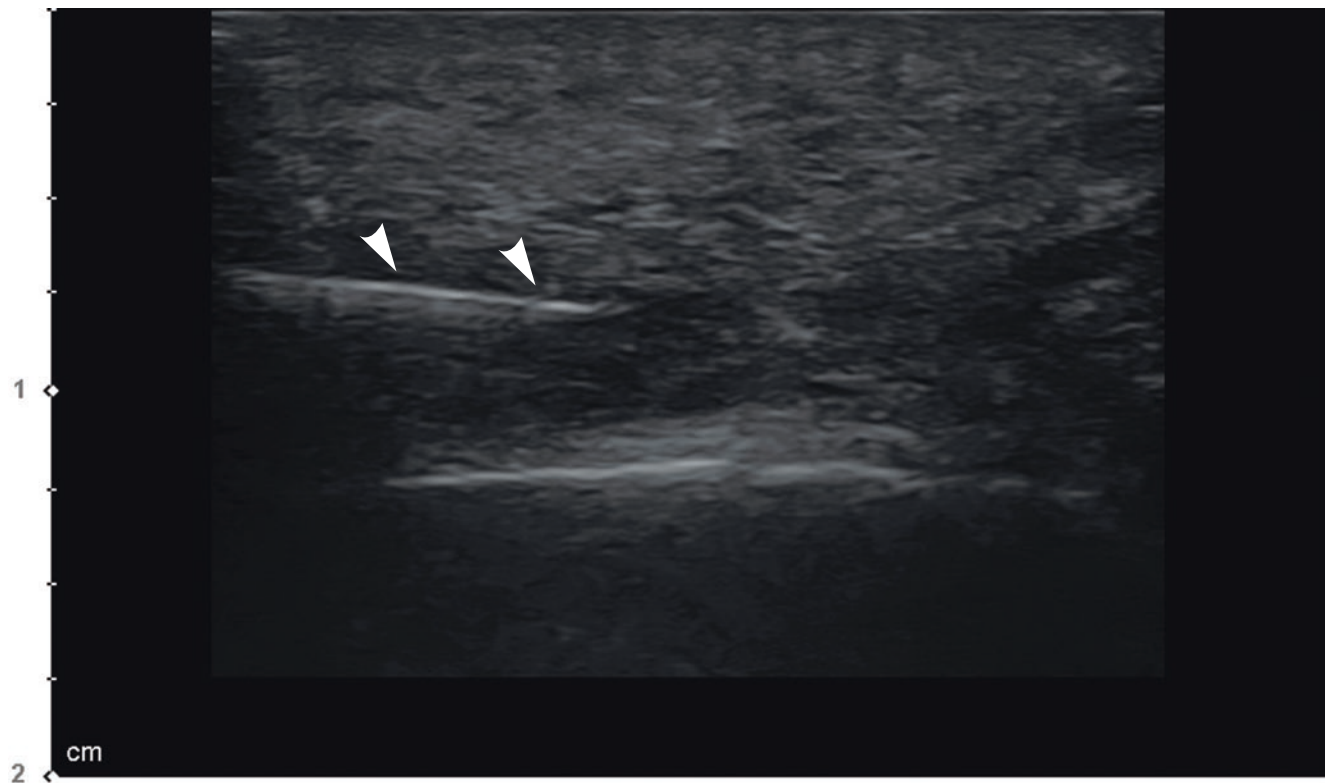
Ultrasonography-guided filler injection of subcutaneous tissue in the chin (arrowheads: injection needle). (Published with kind permission of © Ji-Soo Kim 2020. All Rights Reserved)
